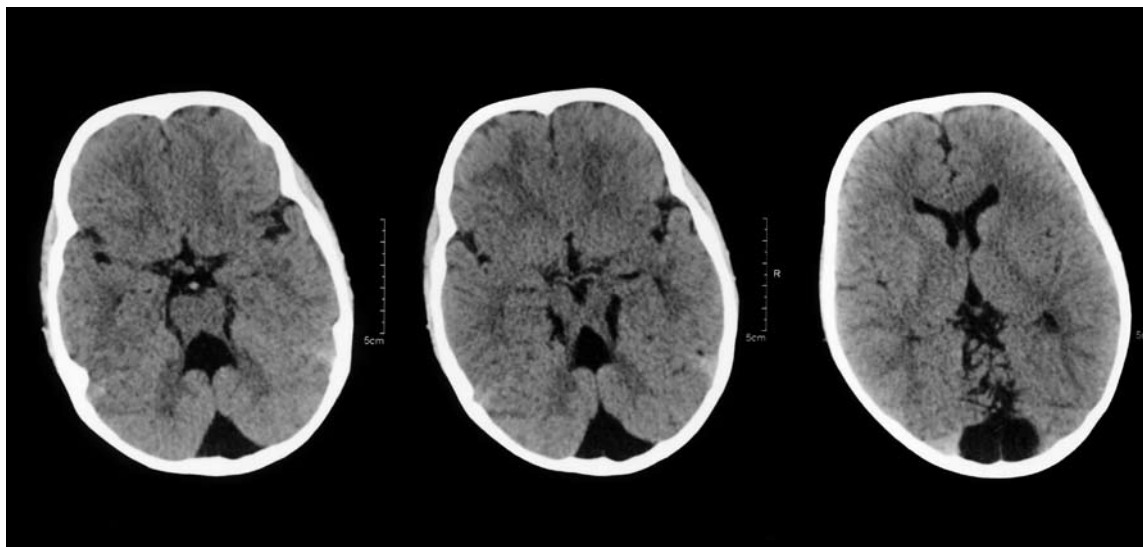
A/B A Brain CT scan performed at 5 years of age. An axial image at the level of the midbrain shows the enlarged superior cerebellar peduncles and the absence of the vermis. This has been called the “molar tooth sign.”
